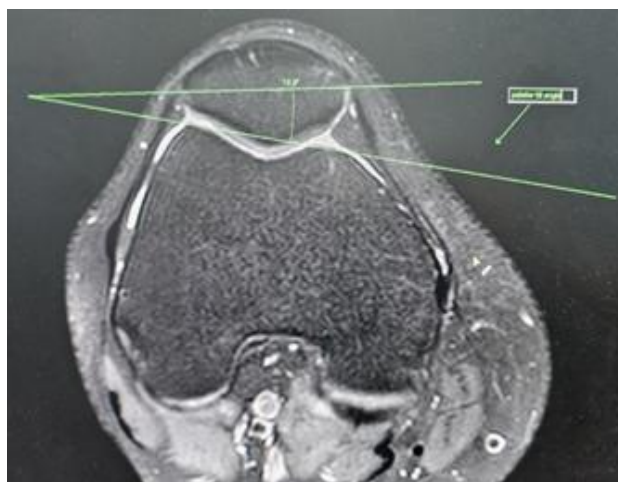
MRI, axial view of Patellar tilt angle.
